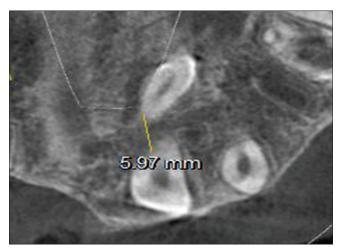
CBCT axial section showing mesiodens at 17° to midline and 6 mm palatal to supplemental tooth to 21
